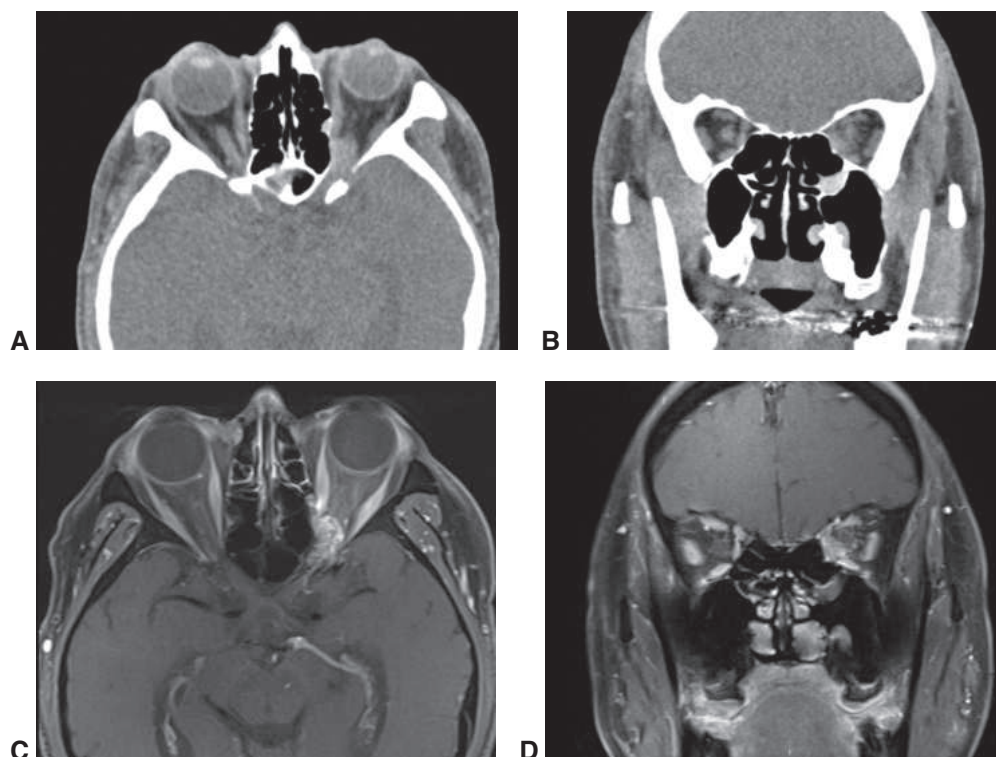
Arteriovenous malformation (AVM) of the left orbit. A, Axial CT image postcontrast with soft-tissue window demonstrates a heterogeneously enhancing intraconal process of the left orbital apex. B, Coronal CT image postcontrast with soft-tissue window shows an intraconal process that is difficult to delineate from the extraocular muscles and optic nerve. C, Axial T1-weighted magnetic resonance (MR) image postcontrast with fat suppression clearly demonstrates an enhancing, heterogeneous lesion of the left orbital apex with intracranial extension through the superior orbital fissure consistent with an AVM. Note the improved soft tissue resolution. D, Coronal T1-weighted MR image postcontrast with fat suppression shows that the AVM lies inferomedial to the optic nerve and has displaced it in a superolateral direction. (Courtesy of Lilangi Ediriwickrema, MD.)
